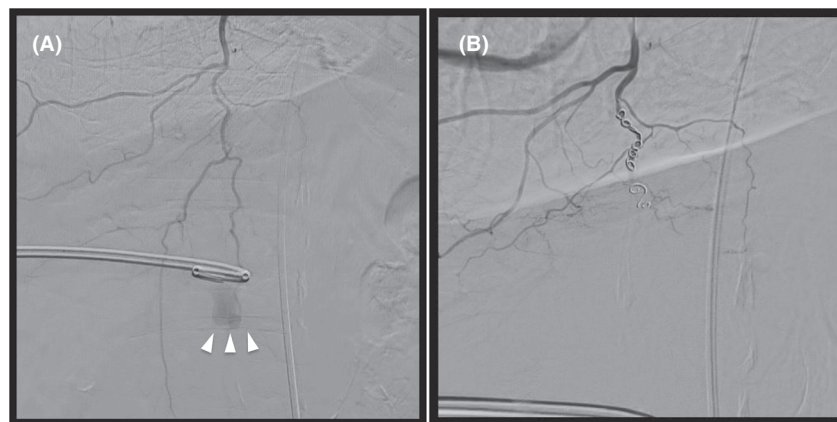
Right internal mammary artery angiogram undertaken before and after percutaneous coil embolization in an 84-year-old man with internal mammary artery injury after ultrasound-guided percutaneous catheter drainage for liver cyst infection. A, Selective right internal mammary artery angiogram at anteroposterior view. White arrowheads show extravasation of right distal internal mammary artery. B, Angiogram after percutaneous coil embolization. Extravasation was completely sealed by implantation of four coils.
